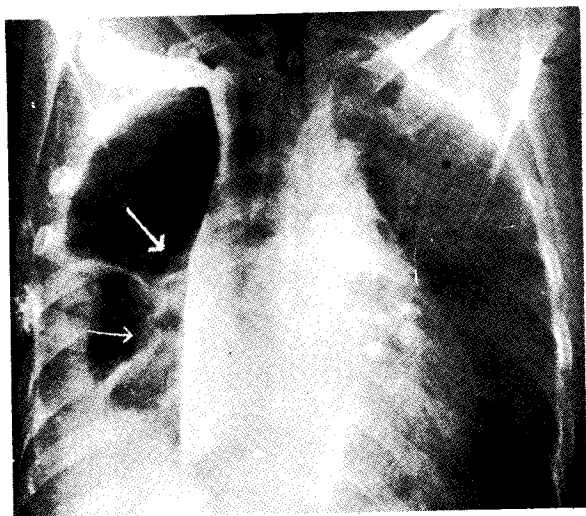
is a plain chest radiograph showing a grossly enlarged heart, provisionally diagnosed as a case of pericardial effusion.
